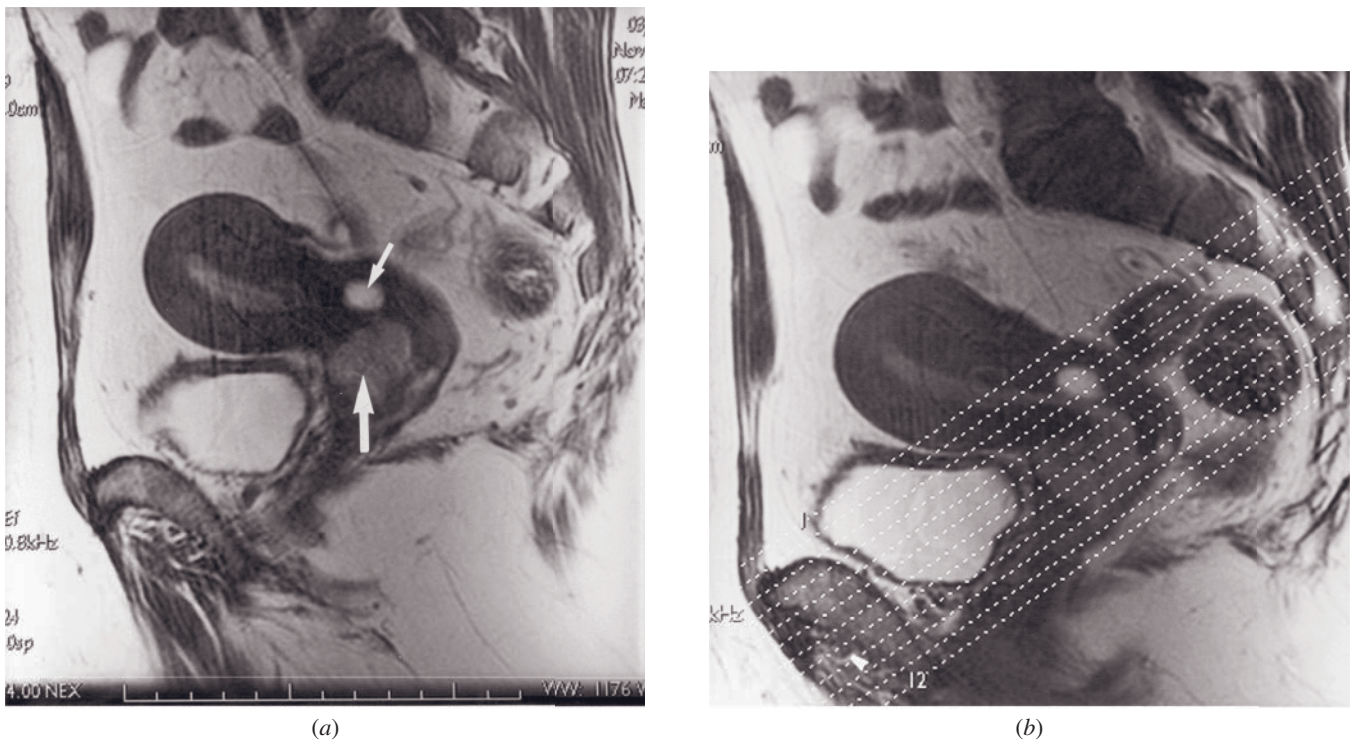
Cervical carcinoma stage IB. Sagittal (a,b) and oblique (c) T2-weighted ETSE images. On the sagittal image, oblique imaging plane perpendicular to the cervical canal is prescribed graphically (b), resulting in a short-axis view of the cervix (c). A tumor (arrow, a) of intermediate signal is seen within the cervix. The tumor is entirely surrounded by normal hypointense cervical stroma (arrowheads, c), excluding parametrial invasion. A nabothian cyst (small arrow, a) is also seen within the cervix.
